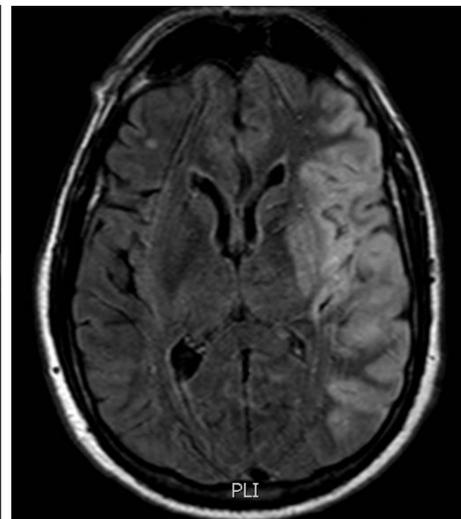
MRI brain with large left MCA territory stroke
